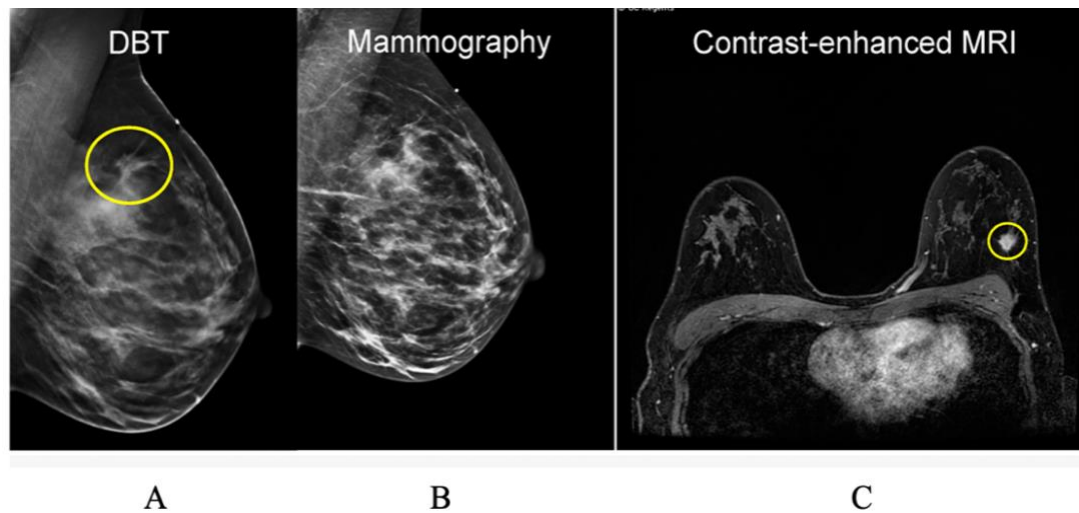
Example of a mammography-occult biologically aggressive cancer visible on DBT and MRI (a) DBT with evidence of breast cancer with asymmetry and architectural distortion. (b) Dense breast tissue obscuring the findings on mammographic image (c) Invasive ductal carcinoma present in the contrast-enhanced MRI (Jones et al., 2020).
